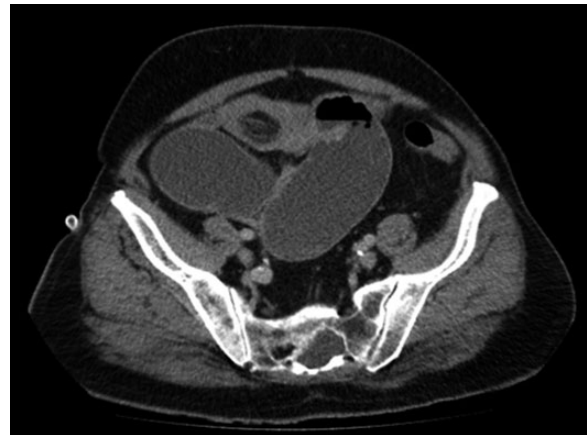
CT showing intussusception secondary to a lesion.
